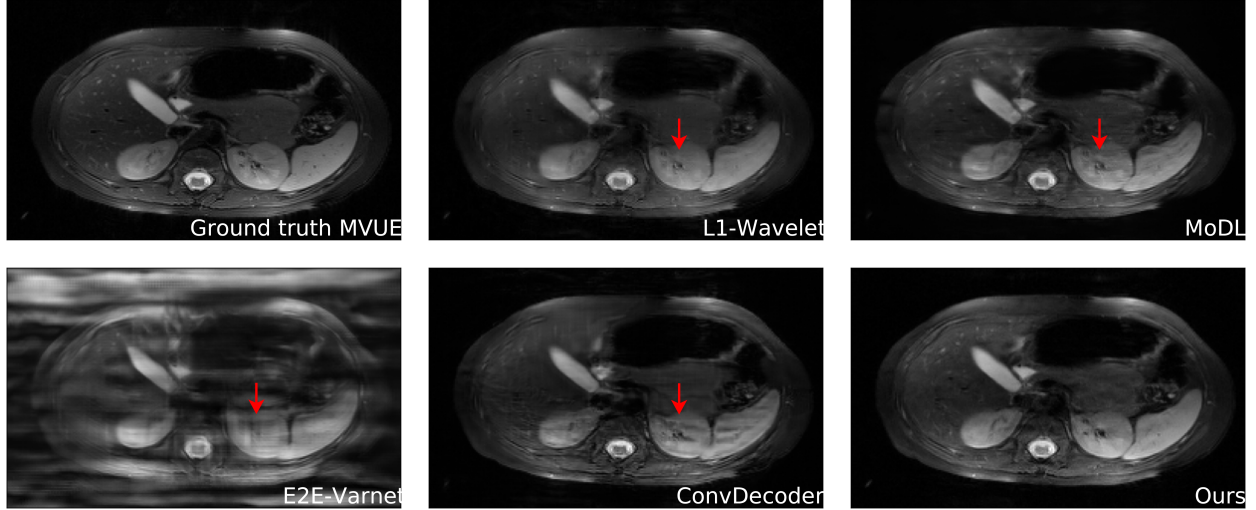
Comparative reconstructions of a 2D abdominal scan with uniform random under-sampling in the horizontal direction at $R = 4$. None of the methods were trained to reconstruct abdomen MRI. Our method uses a score-based generative model trained on brain images (as explained), and obtains excellent qualitative abdomen reconstructions. The red arrows point to artifacts that occur for prior methods and indicate missing details (for ℓ_1 -Wavelet and MoDL) or severe artifacts (for E2E-VarNet and the ConvDecoder) in the kidney structure, which makes these reconstructions unacceptable for clinical use [90].
